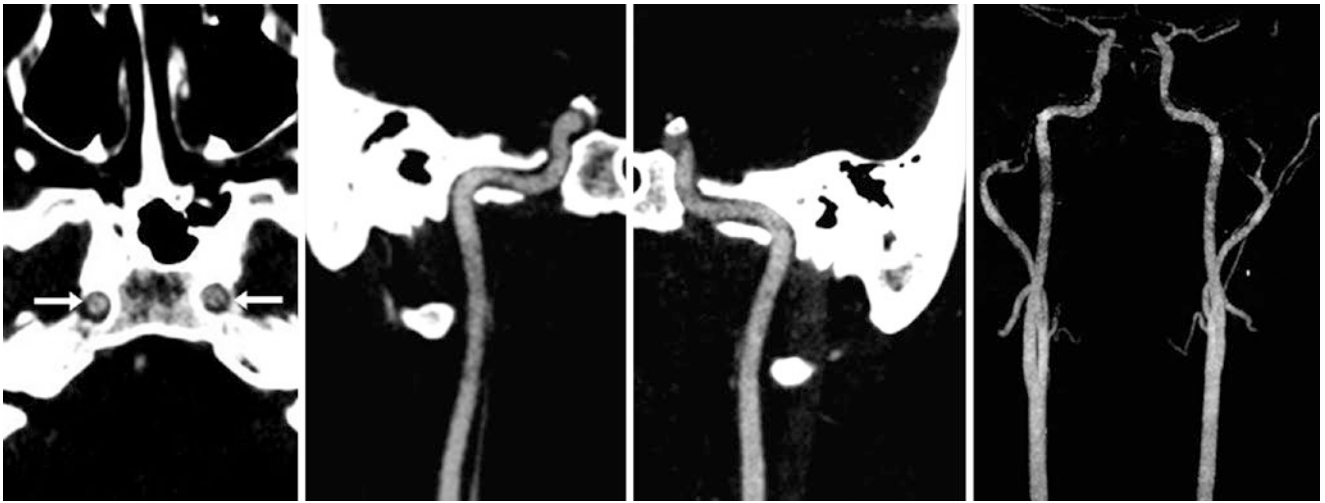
19-year-old with pseudodissection. Axial CTA images depict flow-related “pseudodissections” (arrows) in the petrous ICAs bilaterally because a fast 256-slice CT scanner “outpaces” the contrast bolus. Coronal MPRs of the right ICA (left middle) and left ICA (right
